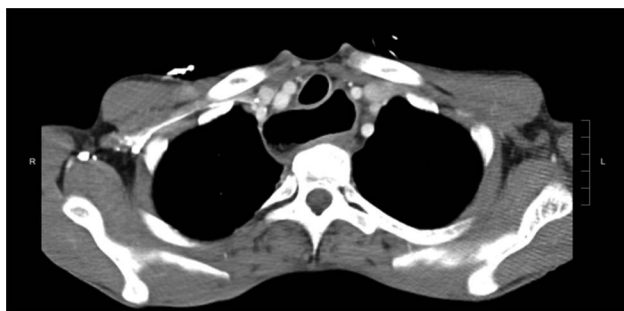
Axial slices of chest computed tomography showing a dilated upper esophagus (inferior to the trachea).
